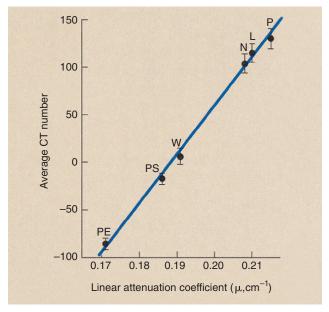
Computed tomography (CT) linearity is acceptable if a graph of average CT number versus the linear attenuation coefficient is a straight line that passes through 0 for water.
